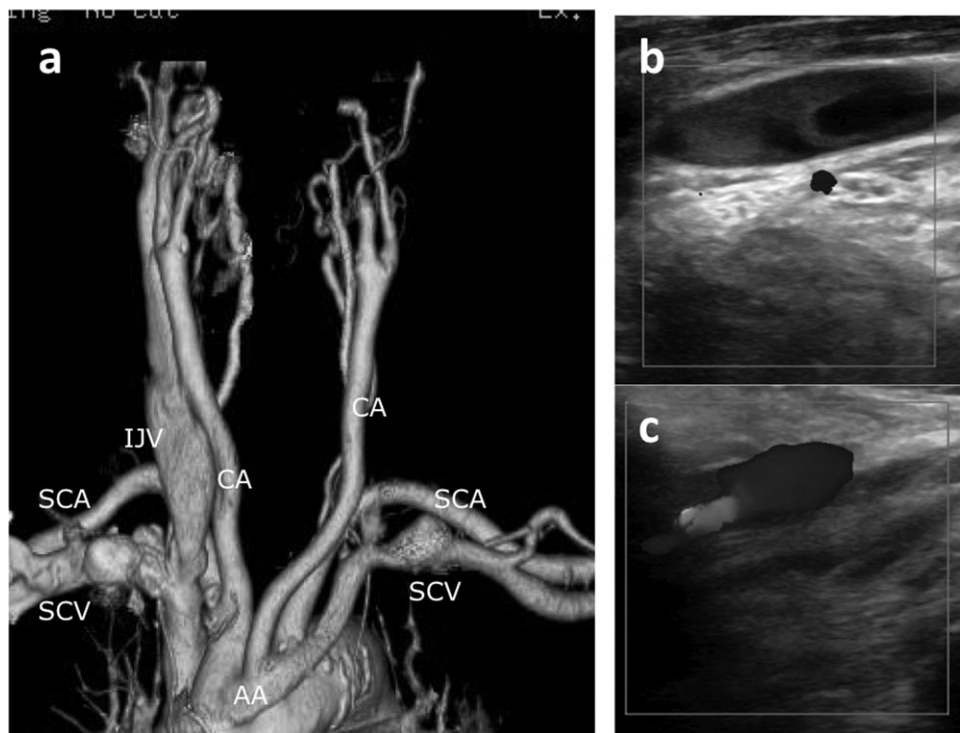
(a) MDCT venography and echo study: AP VR images. The CT-V could not identify the left IJV, the EJV, or the right EJV. The disappearance of the left IJV on CT-V image is characteristic. (b) Flow is demonstrated in the proximal section of the IJV and SCV by an ultrasound study. The Doppler color ultrasound demonstrates significantly turbulent flow with decreased flow velocity of the left IJV (c). No thrombosis was detected.
